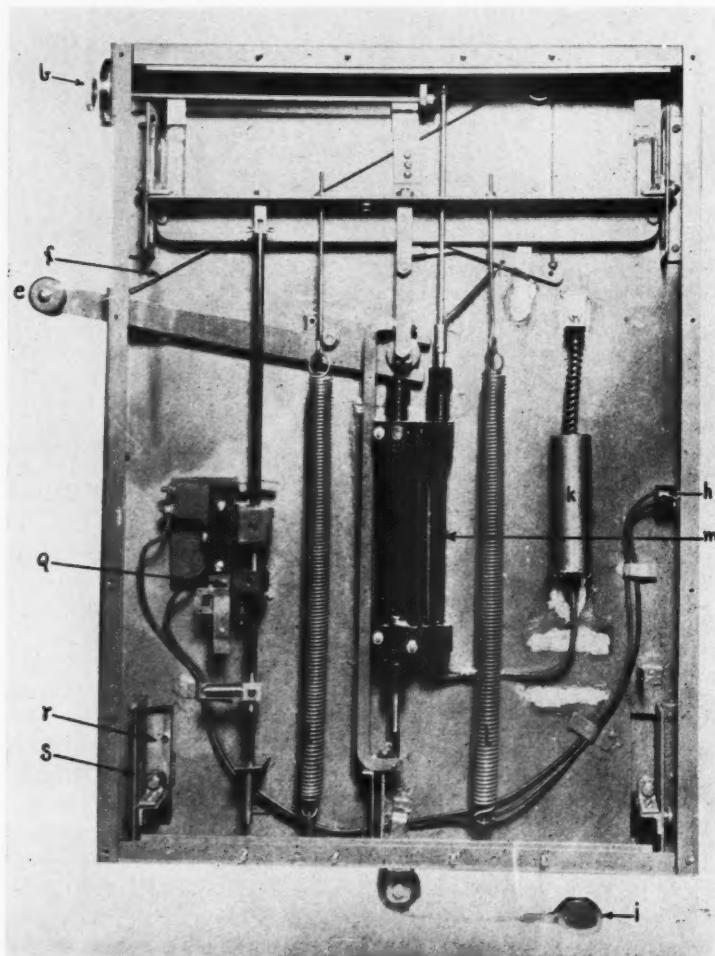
Back view of kymograph after removal of outer casing to show the mechanical details. (k) Siphon; (l) tension springs; (m) Potter-Bucky oil pump; (q) x-ray exposure switch—contacts closed by the downward movement of the cassette frame; (r) back of cassette frame; (s) guide rails for cassette frame.
